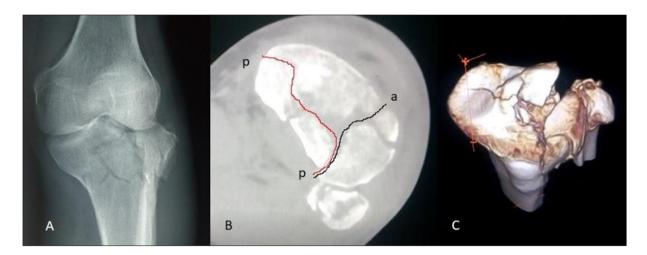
2A: X-ray of a type VI fracture, 2B: axial CT scan of the same fracture showing articular fractures lines , in black (a, p, ax) and in red a fracture with a frontal line (p, p, px) which separates the entire posterior border, divided by a secondary line into posterolateral and posteromedial fragments. 2C: three-dimensional reconstruction, schatzker classification: Type VI AL + PL + PM
